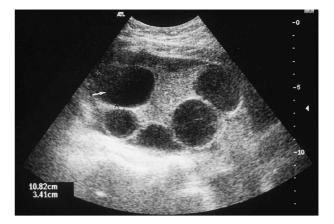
Ultrasound right ovary (white arrow indicates enlarged follicle).
